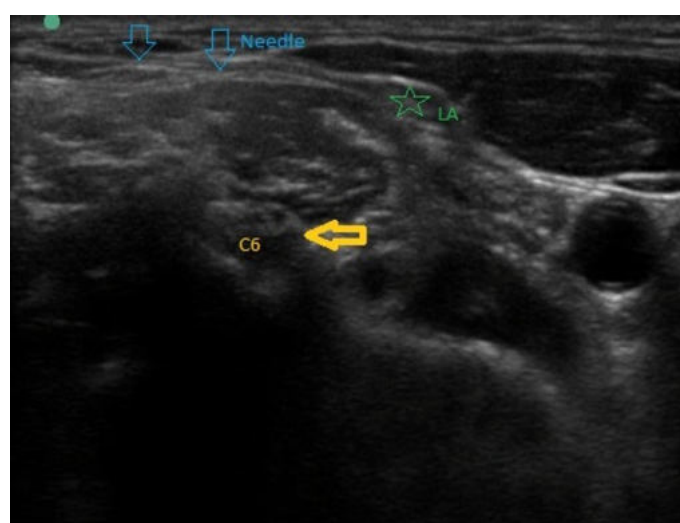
Ultrasound-guided superficial cervical plexus block. LA = local anesthetic, C6 = C6 cervical nerve root.
